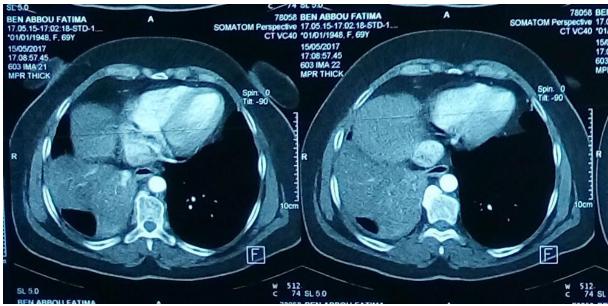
Angiography CT that shows the local extension of adenoid cystic carcinoma of the lung.
